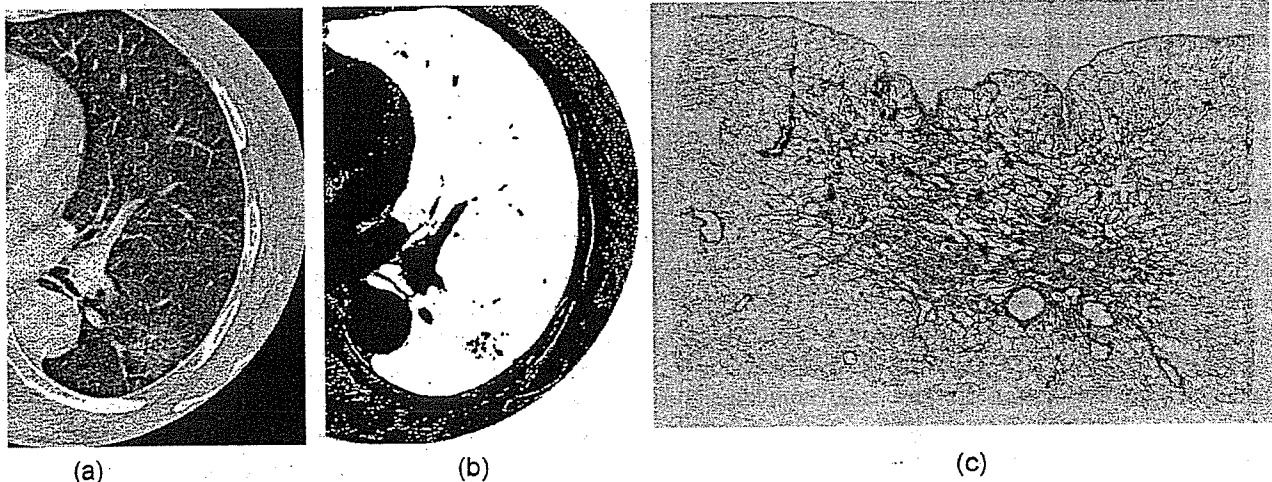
Seventy-seven-year-old woman with a pulmonary nodule detected by annual screening using chest X-ray examination. Her HRCT images showed a GGO nodule dotted with small solid areas (a). The proportion of GGO was calculated at 86% (b). Pathologic examination revealed that the tumor was BAC. She was alive without any sign of recurrence at 42 months after operation (c).
